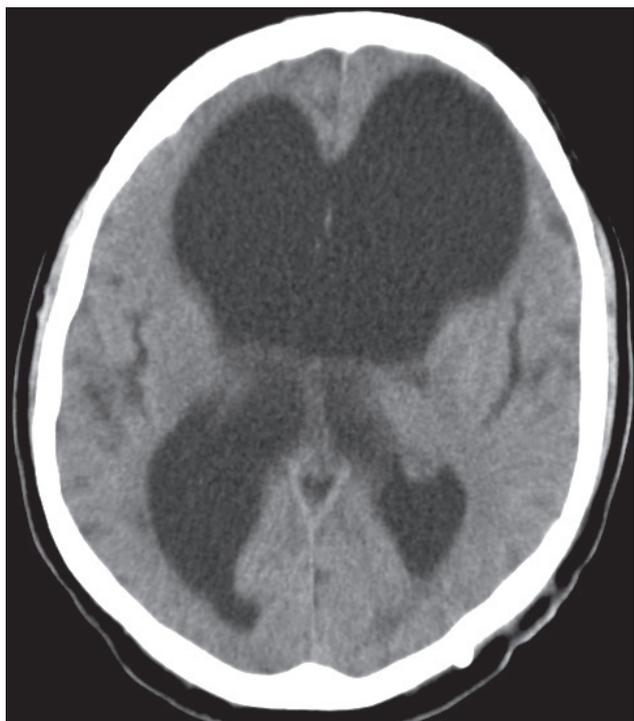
Cranial CT showing spontaneous resolution of subdural hematoma and over dilated frontal horns.
